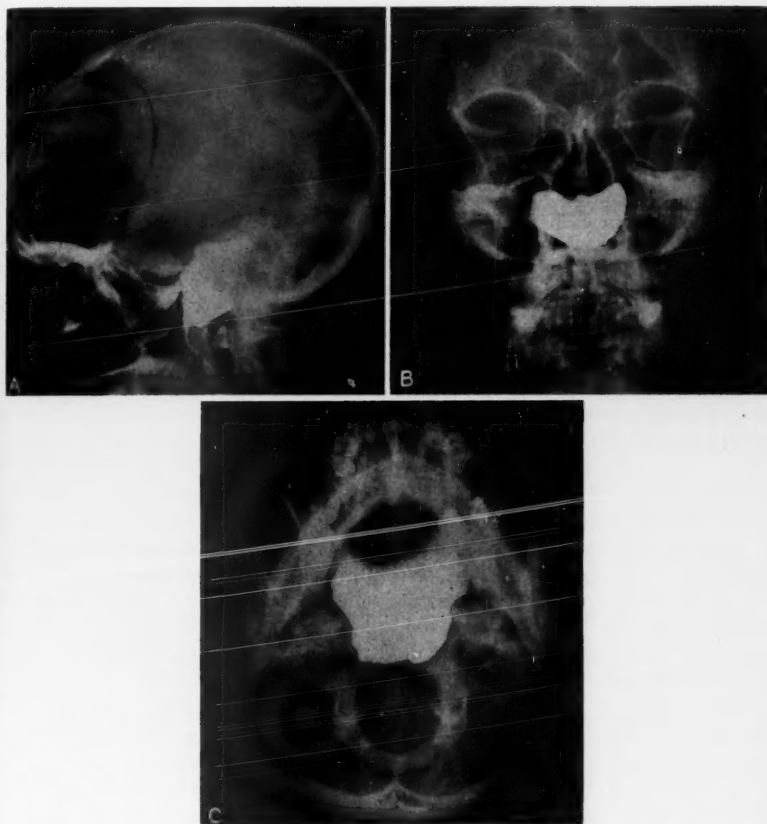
Roentgenogram after instillation of iodized oil six months postoperatively.
